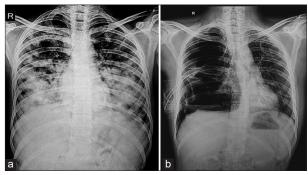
X-ray chest suggestive of bilateral middle and lower zone patchy consolidation
